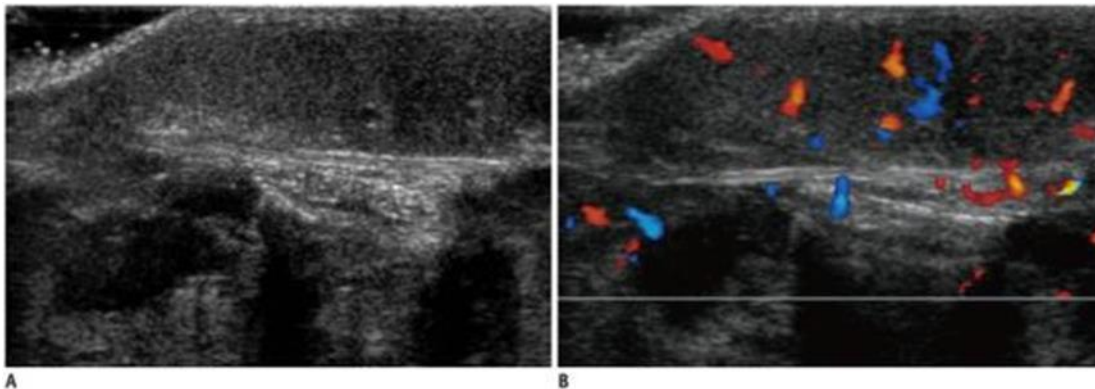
Infantile hemangioma in 8-month-old girl with enlarging foot mass. US (A) shows a well-defined ovoid hypoechoic mass confined to subcutaneous fat. Color Doppler scan (B) shows increased vascular flow [16].
